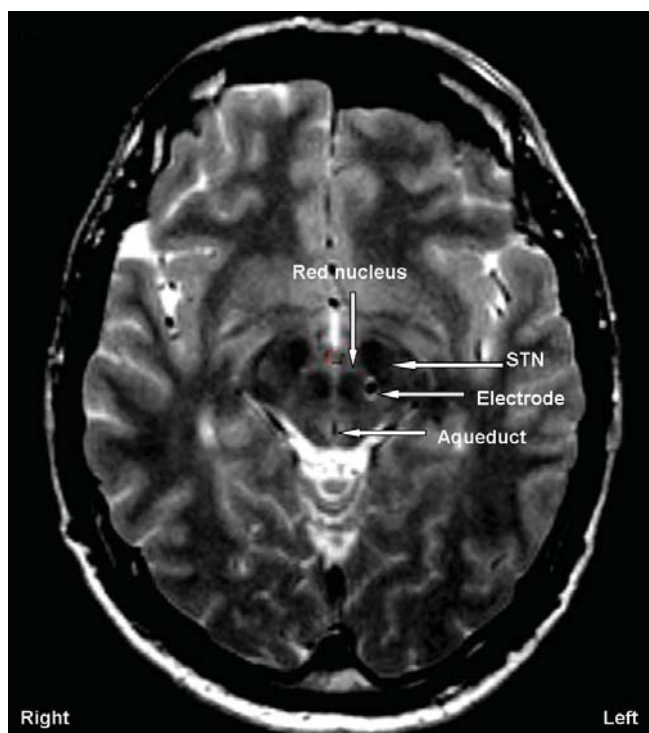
Postoperative MRI demonstrating the electrode in the left posterior subthalamic area in patient 2. (Reprinted with kind permission from the publishers.¹⁵⁹)
